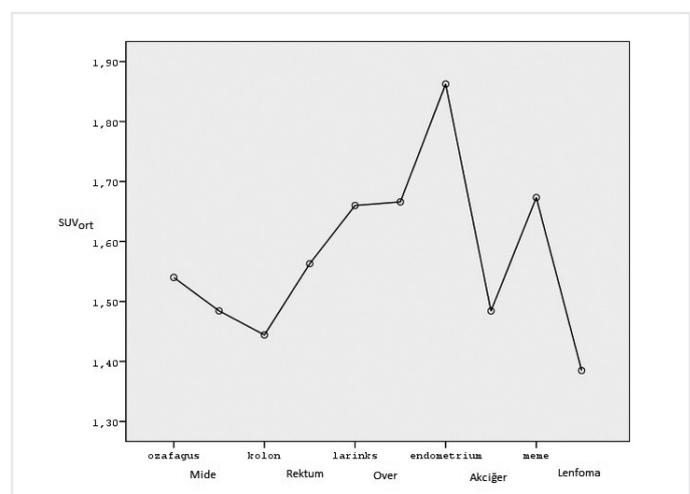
Mean SUV_{mean} measurements of ROIs plotted on aortic arch according to diagnosis
